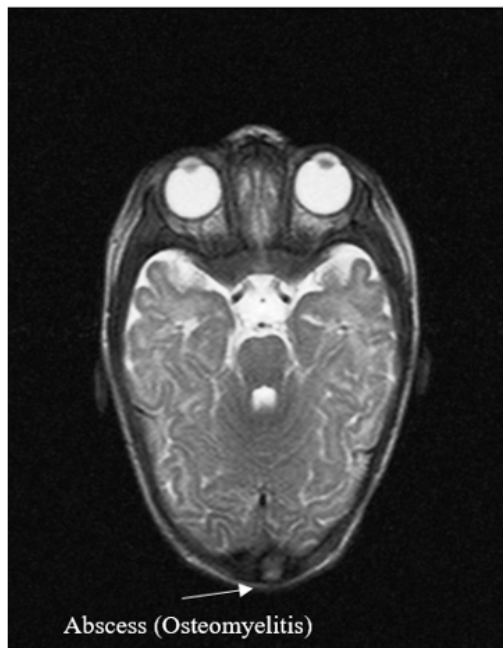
Abscess (osteomyelitis) in MRI skull
